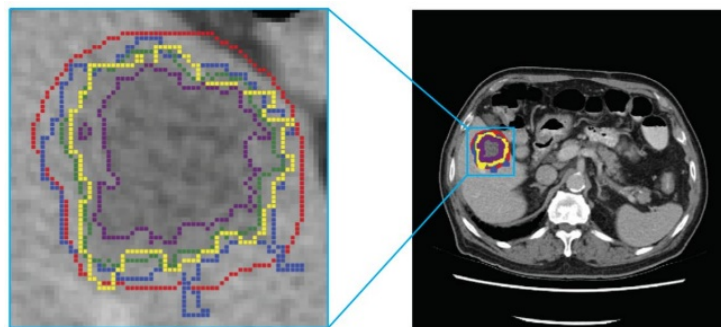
Manual segmentations by multiple observers of a colorectal cancer liver metastasis on an axial slice of a CT image (Starmans et al., 2020)
